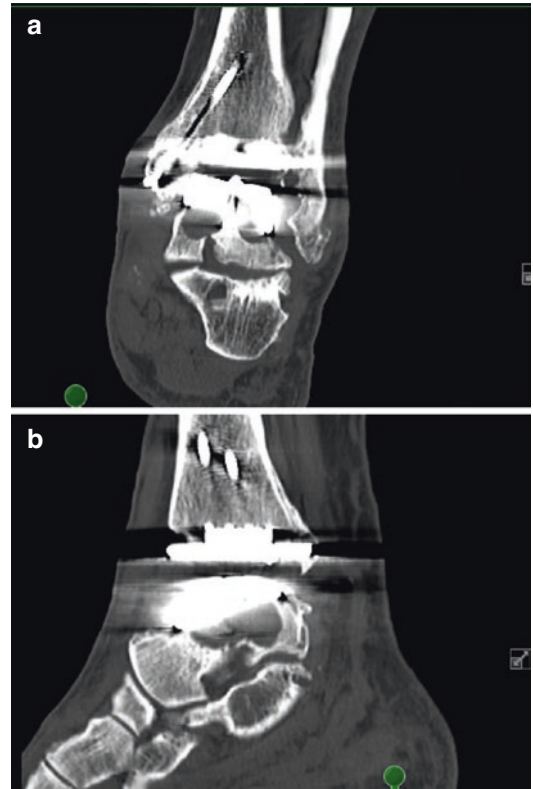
CT demonstrating large talar cysts adjacent to the talar component of a total ankle replacement. (a) Coronal view. (b) Sagittal view
